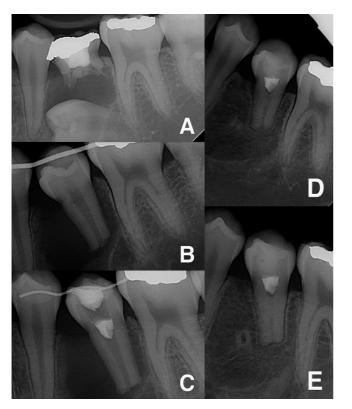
(A) A preoperative periapical radiograph. (B) The transplanted tooth was placed in infraocclusion and fixed with resin and a wire splint following extraction of the impacted tooth. (C) Platelet-rich fibrin (PRF) was inserted into the root canal, and mineral trioxide aggregate was placed directly over the PRF clot. The wire was replaced with a 0.5-mm-diameter twist-flex wire. (D) A postoperative periapical radiograph at 9 months following surgery. (E) At 17 months, continued thickening of the dentinal walls was observed. A continuous lamina dura surrounding the root was also noted, with no resorption at the root surfaces.
